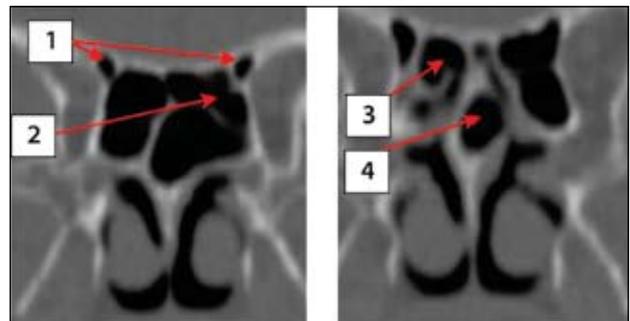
Cranio-facial CT scan, coronal reconstruction. 1. type C supreme turbinate with hyperpneumatization; 2. right superior turbinate; 3. hypertrophic inferior turbinates; 4. paradoxically incurved left superior turbinate; 5. hyperpneumatized type C supreme turbinate with sphenoid sinus communication; 6. hyperpneumatization of the left superior turbinate; 7. type V left nasal septum deviation; 8. hypertrophic middle turbinate; 9. bilateral hypertrophic maxillary sinus mucosa
